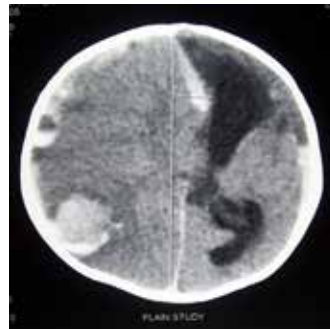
CT brain showing left fronto-temporo-parietal subdural hemorrhage with left ACA and MCA infarct, and a midline shift of 1.3 cms to left with mass effect.
